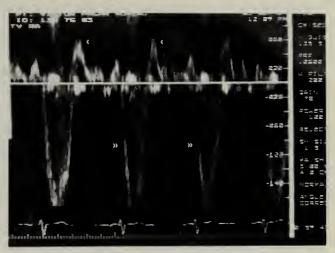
Doppler echocardiogram with the transducer at the apex and the sample volume in the right atrium (RA) showing blood flowing through the TV in diastole (single arrow) and into the RA in systole (double arrow).
